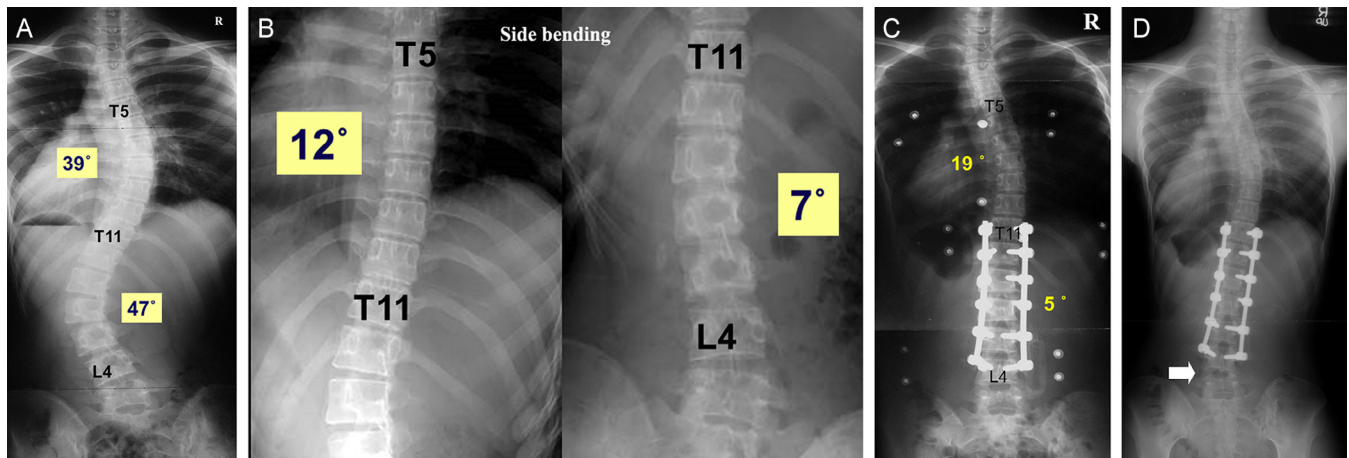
Selective thoracolumbar fusion in a 16-year-old female patient with AIS. (A) A whole-spine anteroposterior radiograph showed double thoracic and TL-L curves. (B) The thoracic curve was found to be flexible on a bending radiograph. (C) A well-balanced spine was noted in the coronal plane in the immediate postoperative period following selective thoracolumbar fusion (T11–L4). (D) However, asymmetrical disc wedging was also observed just inferior to the lowest instrumented vertebra at 1.5 years postoperatively (arrow).
